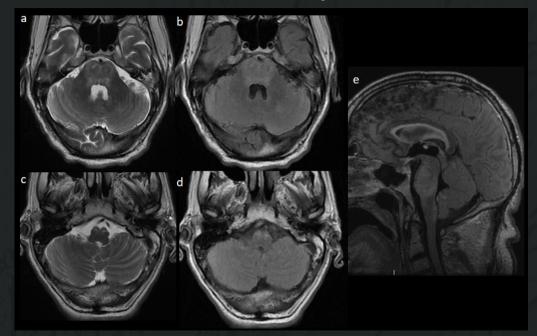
64-year-old male with subacute loss of consciousness associated with behavioral and language disorder associated with meningeal signs. Bickerstaff encephalitis on axial T2-weight image (a, c), axial Flair (b, d) and sagital 3D Flair (e) on 1,5T MRI. T2 and Flair pontine hyperintensity affecting the area postrema and cerebellar tonsils. Small T2 and Flair hyperintensity of the interthalamic adhesion and subthalamic area (e).
